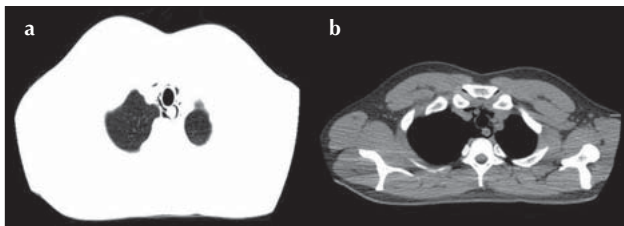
a, b Mediastinal emphysema and subcutaneous emphysema in thoracic CT of case 1.
